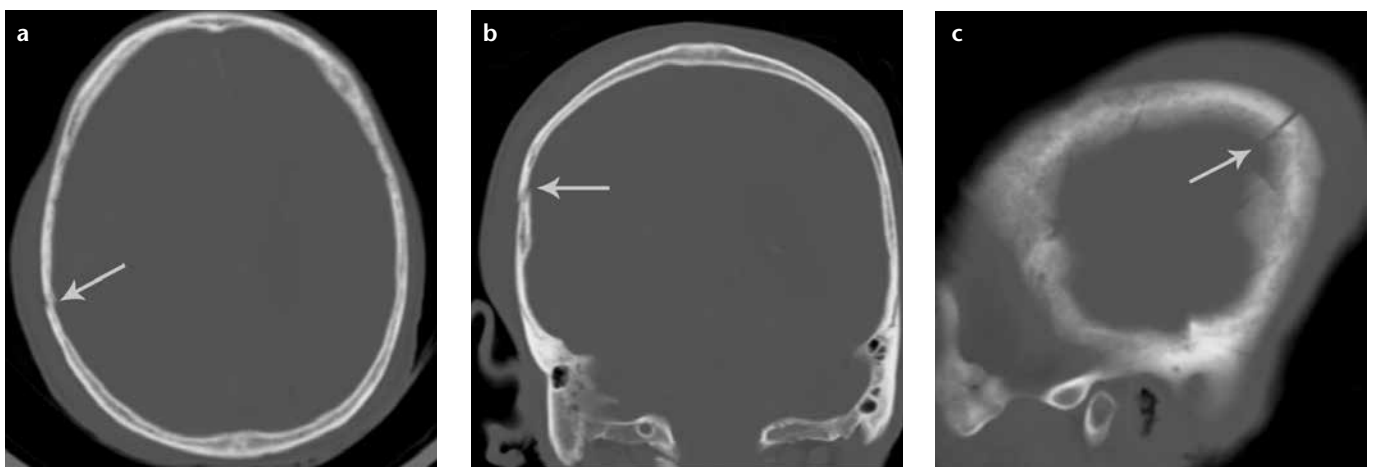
a–c. An 82-year-old male with head trauma. Unenhanced transverse CT image with a bone window setting (a) shows a fracture line (*arrow*) in the right parietal region. The neuroradiologist and a radiology resident identified a fracture in the transverse plane (missed by two residents). Coronal (b) and sagittal (c) reformatted images clearly show a linear fracture (*arrows*) through the right parietal bone, which was identified by all four readers.
